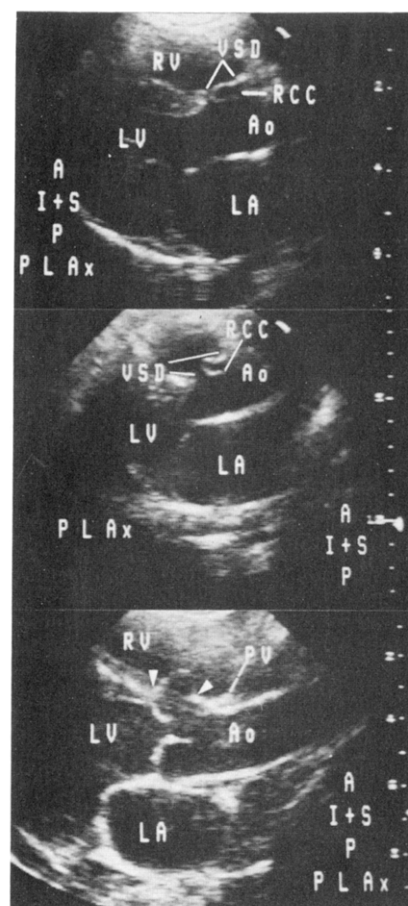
Two-dimensional echocardiographic display of different degrees of aortic valve herniation in three patients with a doubly committed subarterial ventricular septal defect (parasternal long-axis views, PLAx). Top (Patient 48), Mild aortic valve herniation with only little anterior deviation of the right sinus of Valsalva is seen. The ventricular septal defect (VSD) is apparently small but is mostly obscured by the herniated sinus and measures actually about 8 mm in diameter. Middle (Patient 29), Moderate herniation of the right sinus and the right coronary cusp (RCC) into the ventricular septal defect (VSD) is displayed. Bottom (Patient 20), Severe aortic valve herniation into the outflow tract of the right ventricle (RV) is seen in early systole. The arrowheads mark the boundaries of the ventricular septal defect, which lies directly inferior to the pulmonary valve (PV) but is completely obscured by the herniated right sinus. A = anterior; Ao = aorta; I = inferior; LA = left atrium; LV = left ventricle; P = posterior; S = superior.
